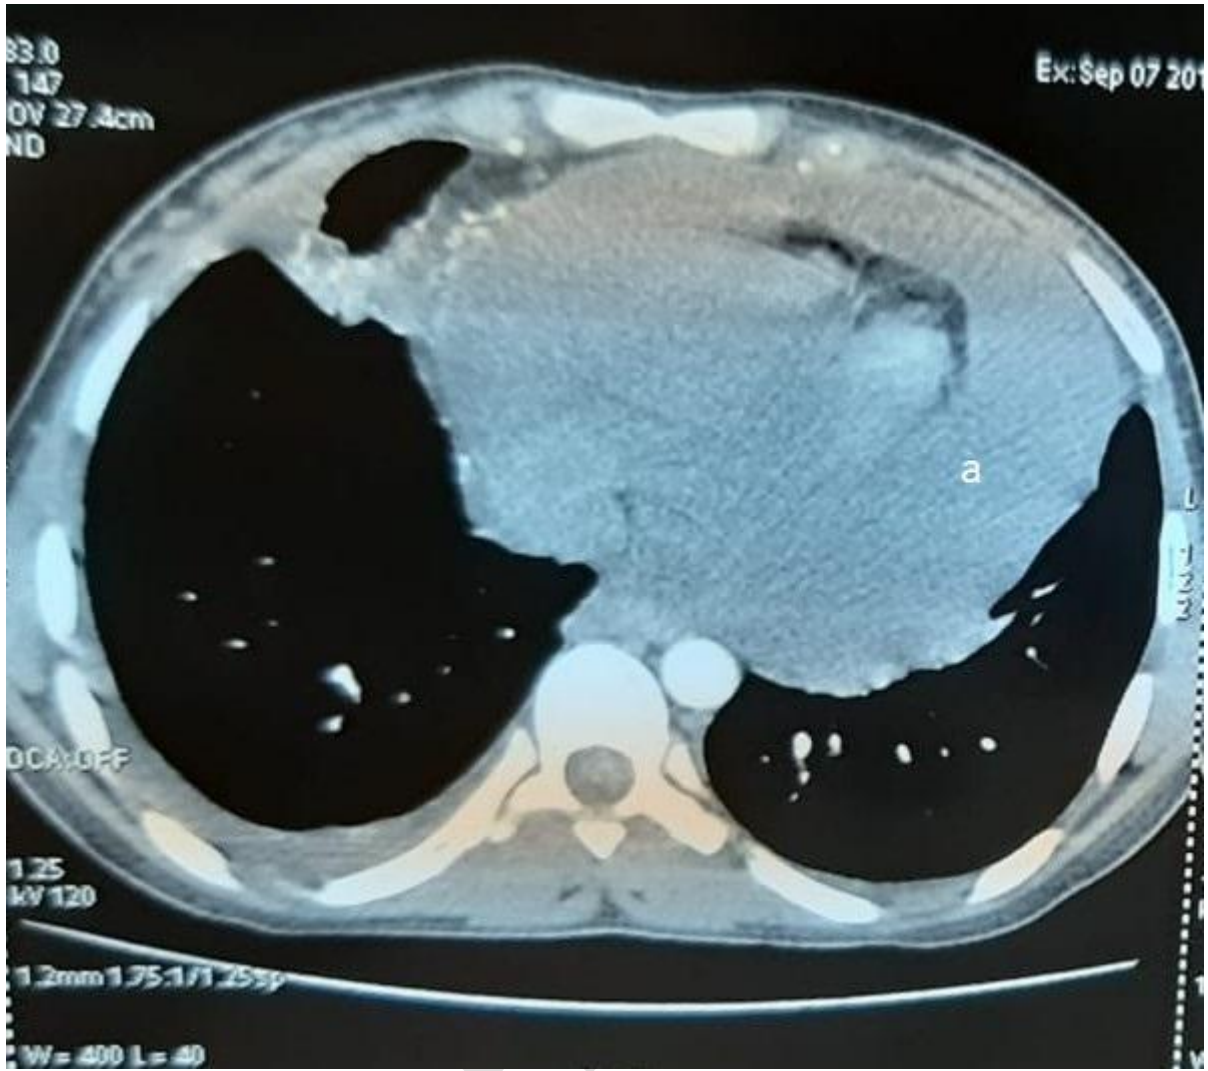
Chest CT scan showing pericardial effusion
